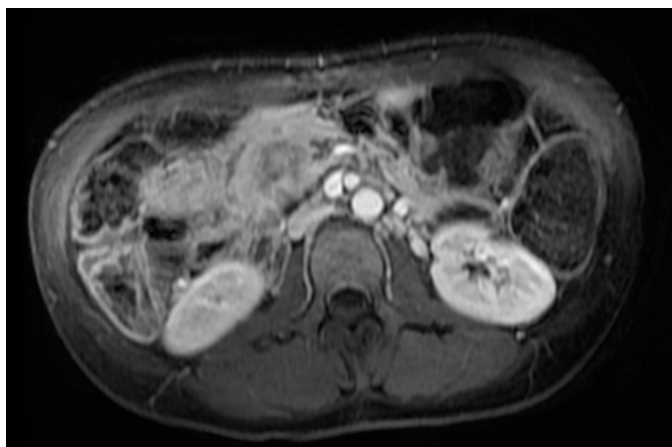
2017 MRI. Axial cut, T1-weighted after contrast, showing a new solid and heterogeneous lesion, with peripheral post-contrast enhancement and with tendency to homogenization in the late phases, on topography of the head/uncinate process of the pancreas.
